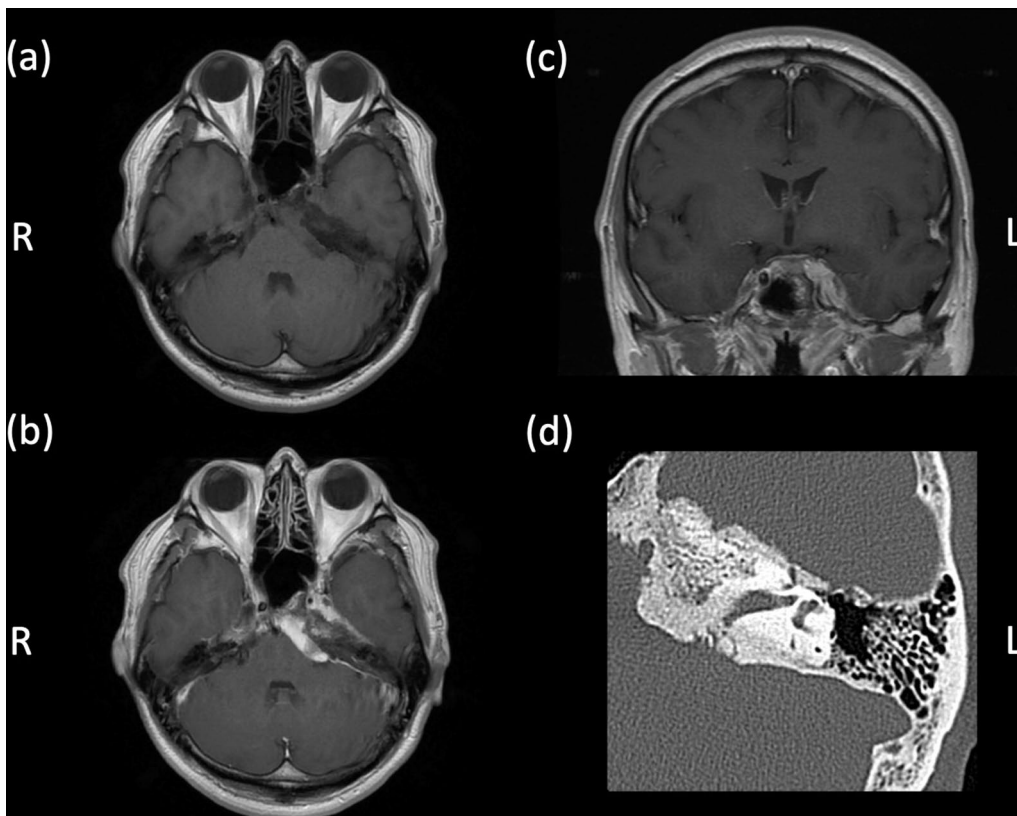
Preoperative images of the cavernous sinus tumor 7 years after gamma-knife radiosurgery. a Axial image of T1-weighted brain MRI. b Axial view of gadolinium-enhanced T1-weighted brain MRI demonstrates that the tumor enlarged slightly toward the posterior fossa. c Coronal view of gadolinium-enhanced T1-weighted MRI. d Axial view of CT demonstrates progression of petrous bone thickening in internal auditory meatus
